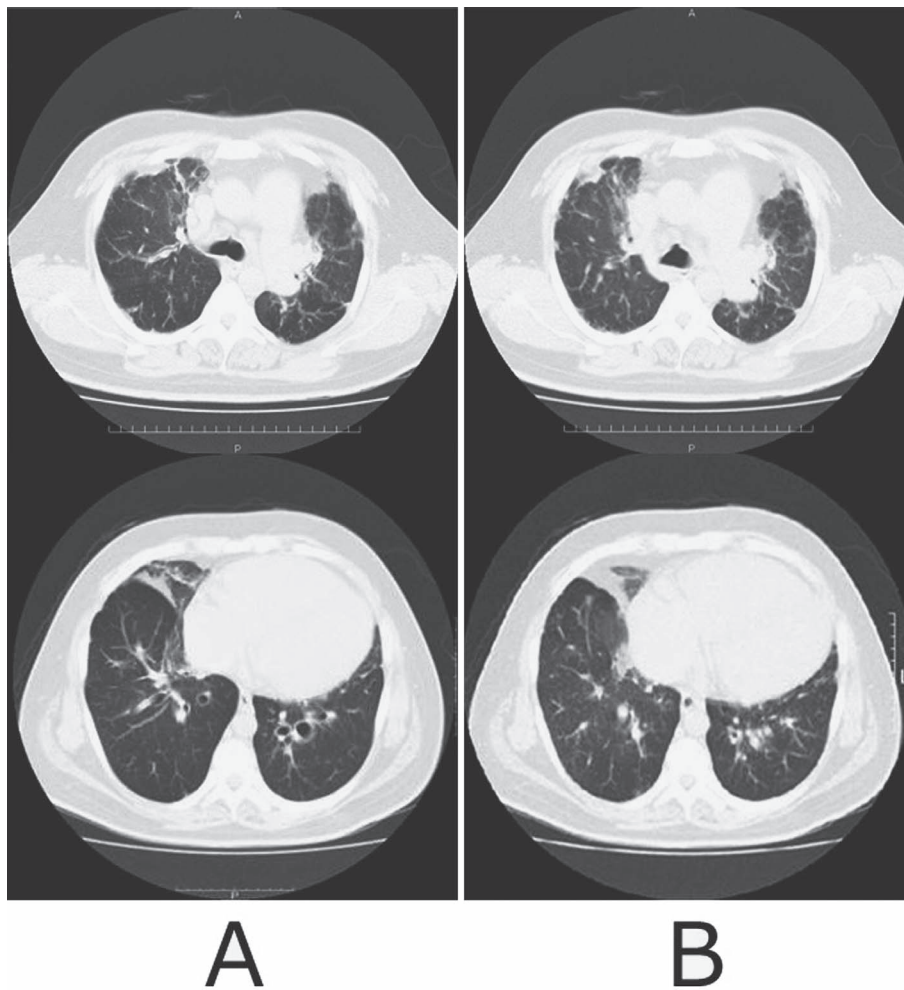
Chest CT in both the inspiratory and expiratory phase. Chest CT showed reticular shadow in bilateral upper and middle lobe. Inspiratory CT (A) shows bronchiectasis and expiratory CT (B) shows collapse of the affected bronchi.
